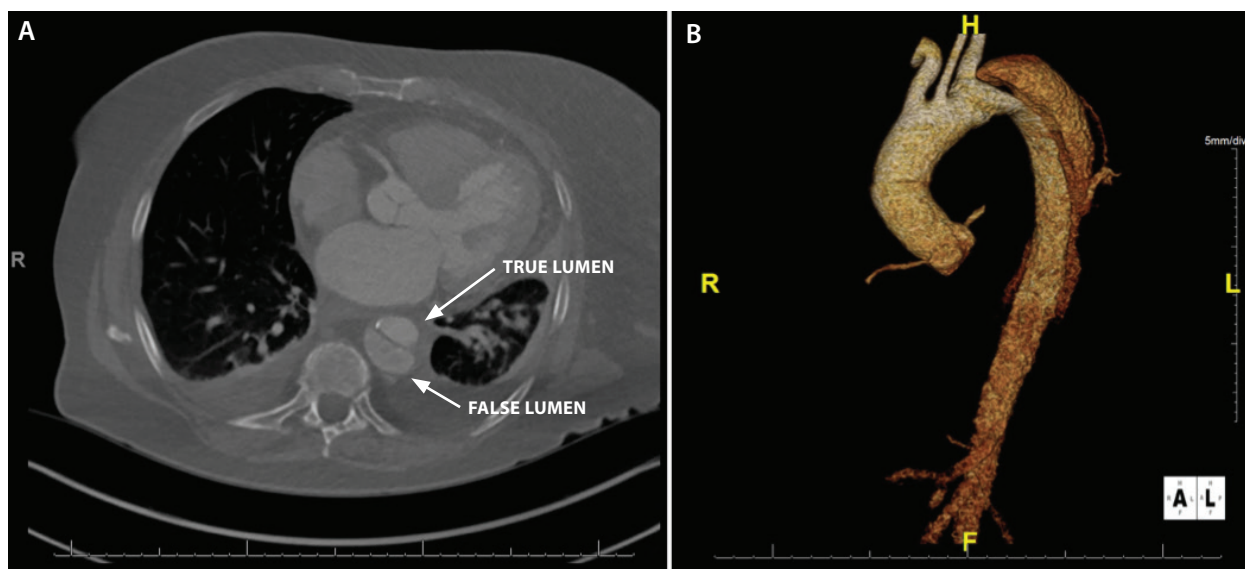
CTA demonstrating a TBAD in the descending thoracic aorta with a classic double barrel. The true lumen is the smaller lumen (A). Three-dimensional reconstruction demonstrating the extent of the TBAD from the distal arch down to the abdominal aorta (B).
